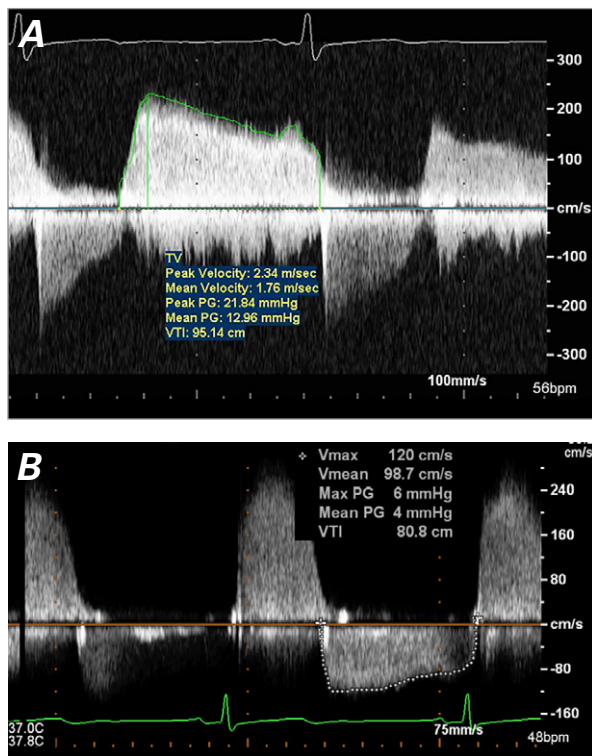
Transesophageal echocardiograms. A) Preprocedural image shows a peak gradient of 21.84 mmHg and a mean gradient of 12.96 mmHg. B) After the 26-mm Edwards SAPIEN® bio-prosthesis was deployed, the peak gradient fell to 6 mmHg with a mean gradient of 4 mmHg.
